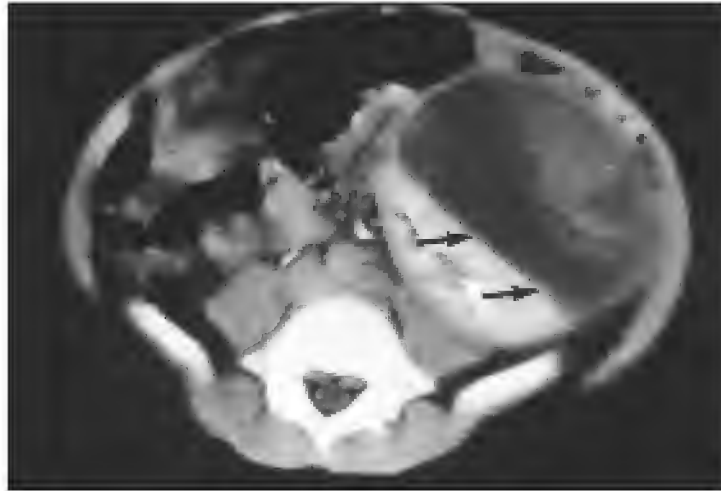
Computed tomography revealing left renal tumor replacing most of the medial portion of the organ (Wilms' tumor).
